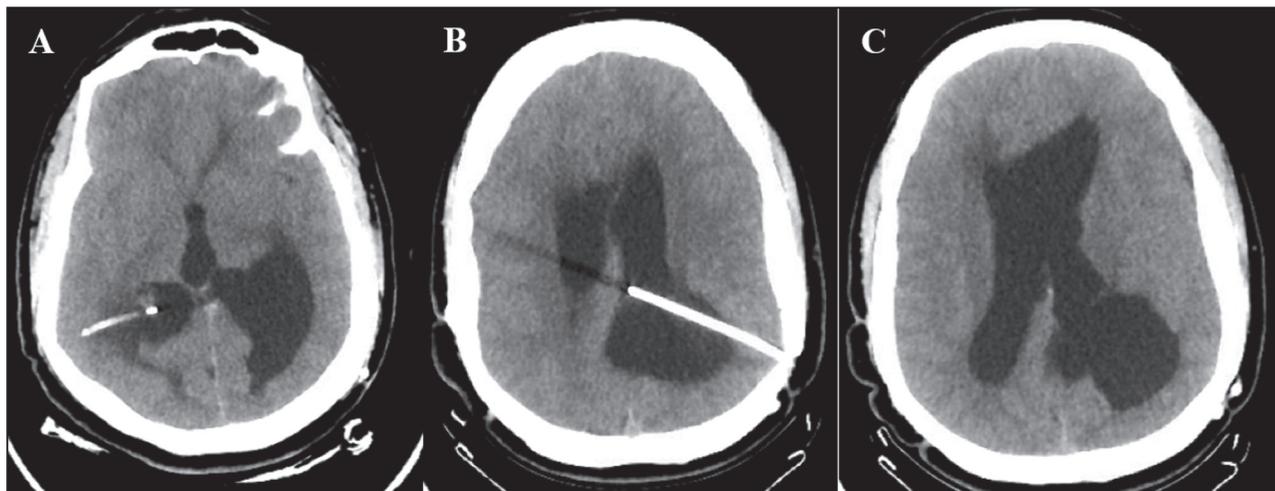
(A-C) Preoperative axial head computed tomography (brain window) images display the course of ventriculoperitoneal shunt and enlargement of cerebral ventricles secondary to suspected shunt occlusion or malfunction
